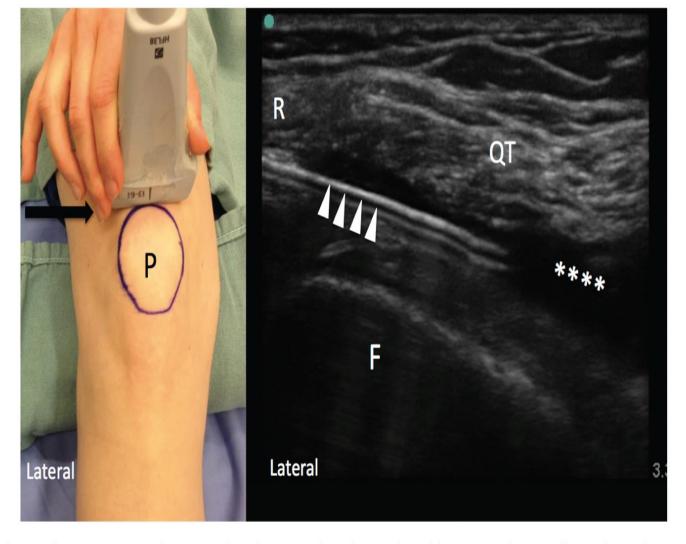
Picture shows the injection technique. The ultrasound probe is placed between the patella and quadriceps tendon initially and then turned 90 degrees upon visualization of the SPR. The needle is then approached from lateral to medial to avoid puncturing the quadriceps tendon. The needle is indicated by the arrowheads and the SPR by asterisks (). R indicates retinaculum; Q, quadriceps tendon; F, femur. Reproduced with permission from Dr Philip Peng from Philip Peng Educational Series.
